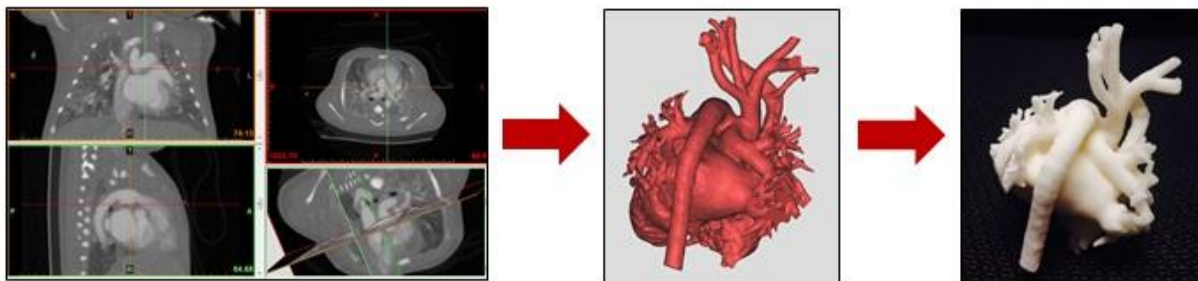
3D Printing Techniques. This series of images depicts how a CT/MR data set is transformed into a virtual 3D reconstruction and subsequent 3D-printed model.
